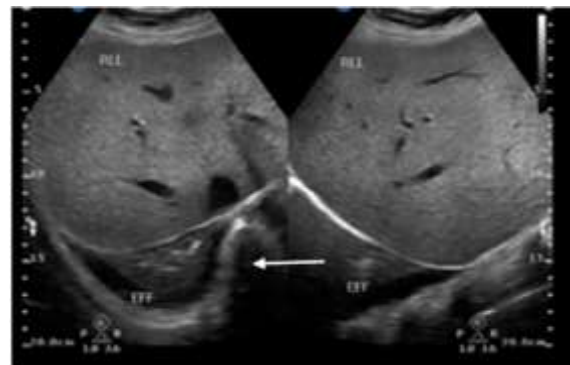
The ultrasound results of research subjects 3 with a description of dextra pleural effusion.
